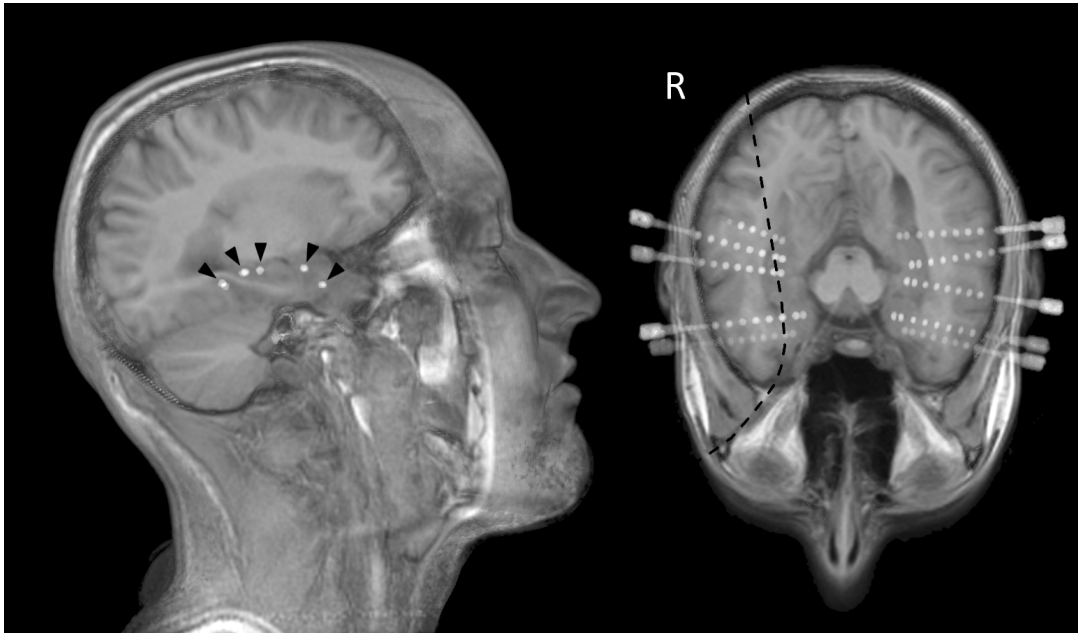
Example of a typical depth-electrode placement in MTLE. Fusion of a pre-operative structural MRI and a coregistered post-operative CT rendered by using volumetric ray casting. From anterior to posterior, electrodes were placed bilaterally in the entorhinal cortex, the amygdala, the anterior and middle hippocampus, as well as the parahippocampal cortex. Arrow heads point to the electrodes' macro-contacts. The dashed line in the axial view reflects the cut in the sagittal view.
